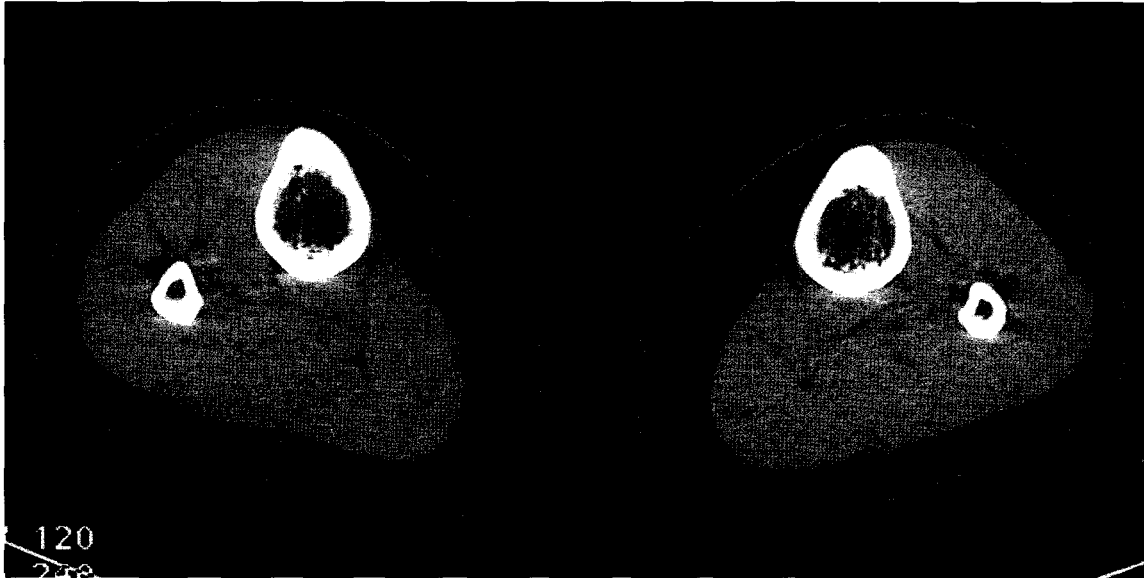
Unenhanced CT scan of bilateral lipodystrophy of the lower limbs. Bilateral subcutaneous enlargement without skin thickening nor subcutaneous fat infiltration.
